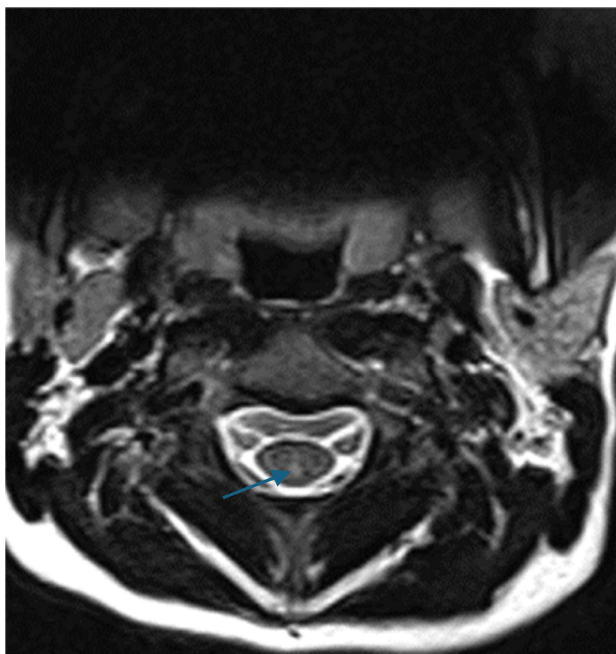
Axial view of the cervical MRI with an arrow pointing at a C2 cervical lesion opposite to C2 vertebra.
